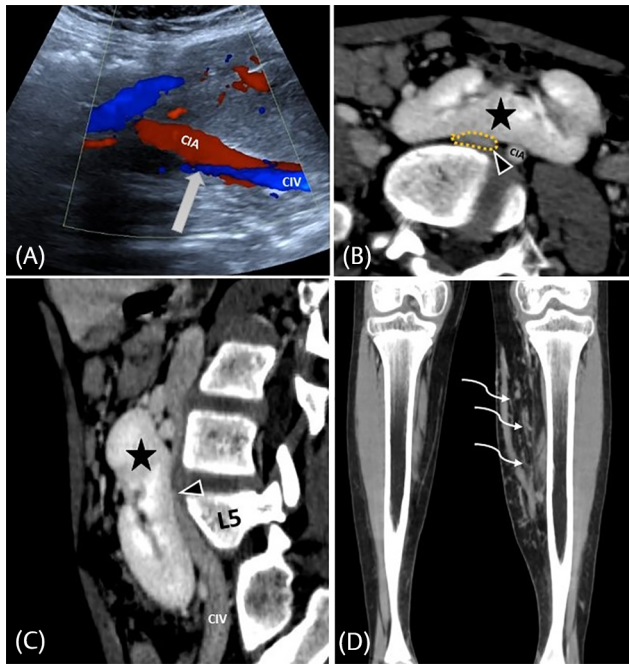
(A) Abdominal ultrasound with color Doppler revealed an ectopic left pelvic kidney, causing compression of the proximal left common iliac vein (CIV) (white solid arrow) in supine position. (B, C) Computed tomography axial and sagittal sections confirmed significant extrinsic compression of the left CIV (yellow dotted line) (B, C) by the ectopic malrotated left pelvic kidney (black star) against the L5 vertebra. (D) Coronal computed tomography sections showing varicose veins in the medial aspect of the left leg (curved white arrows).
